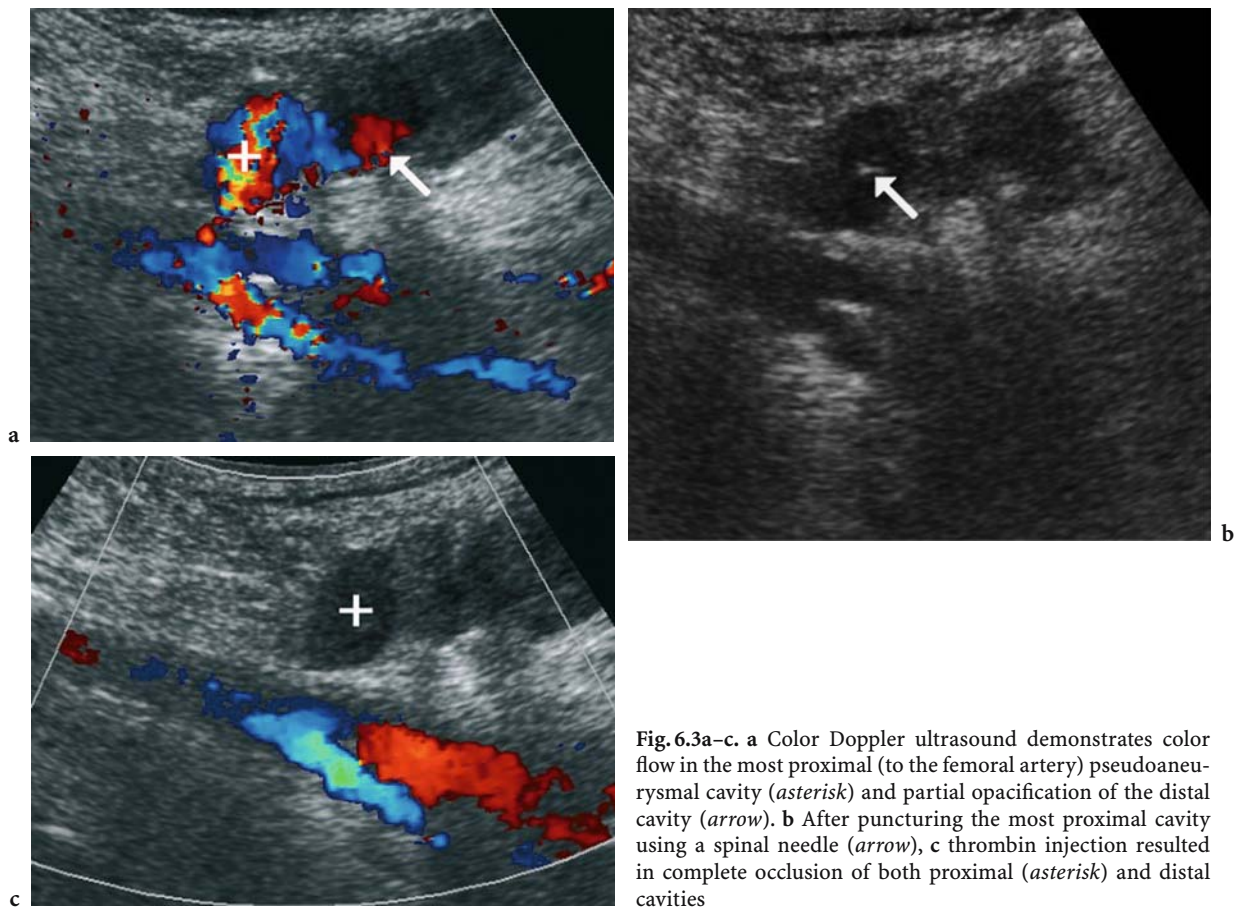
a Color Doppler ultrasound demonstrates color flow in the most proximal (to the femoral artery) pseudoaneurysmal cavity (*asterisk*) and partial opacification of the distal cavity (*arrow*). b After puncturing the most proximal cavity using a spinal needle (*arrow*), c thrombin injection resulted in complete occlusion of both proximal (*asterisk*) and distal cavities
